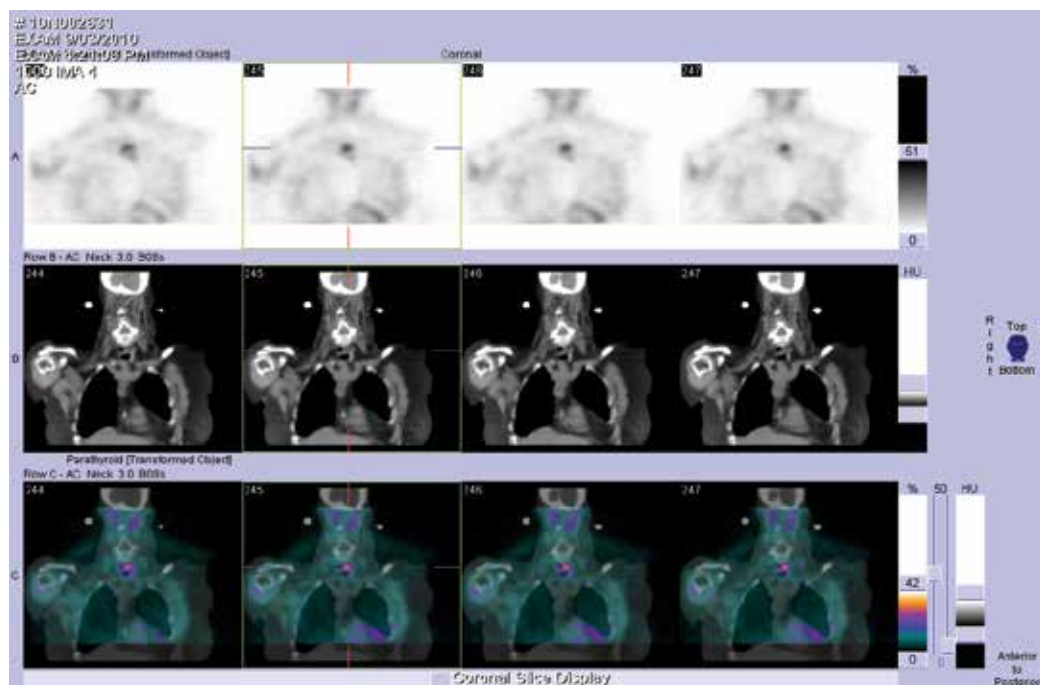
SPECT/CT parathyroid Nuclear Medicine scan demonstrating parathyroid lesion in superior mediastinum. Image courtesy of Royal Adelaide Hospital, Department of Nuclear Medicine, PET & Bone Densitometry
